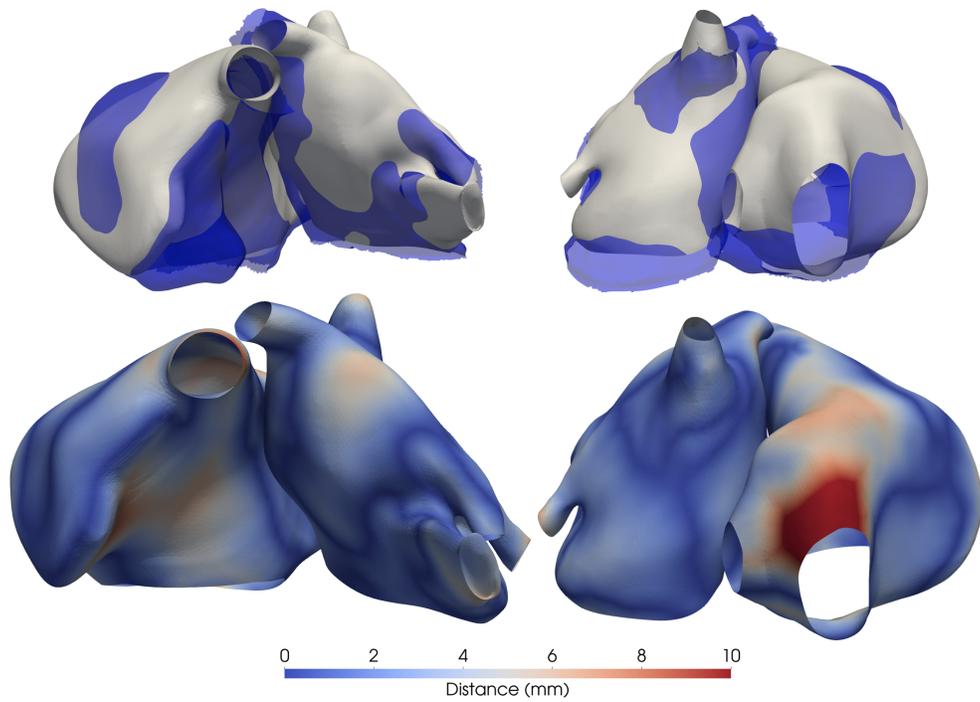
Top row: anterior (left) and posterior view (right) of the best fitting SSM instance (grey) to the target MRI segmentation (semi-transparent blue). Bottom row: anterior and posterior view of the surface-to-surface distance between fitted SSM instance and target mesh shown on the fitted SSM instance.
